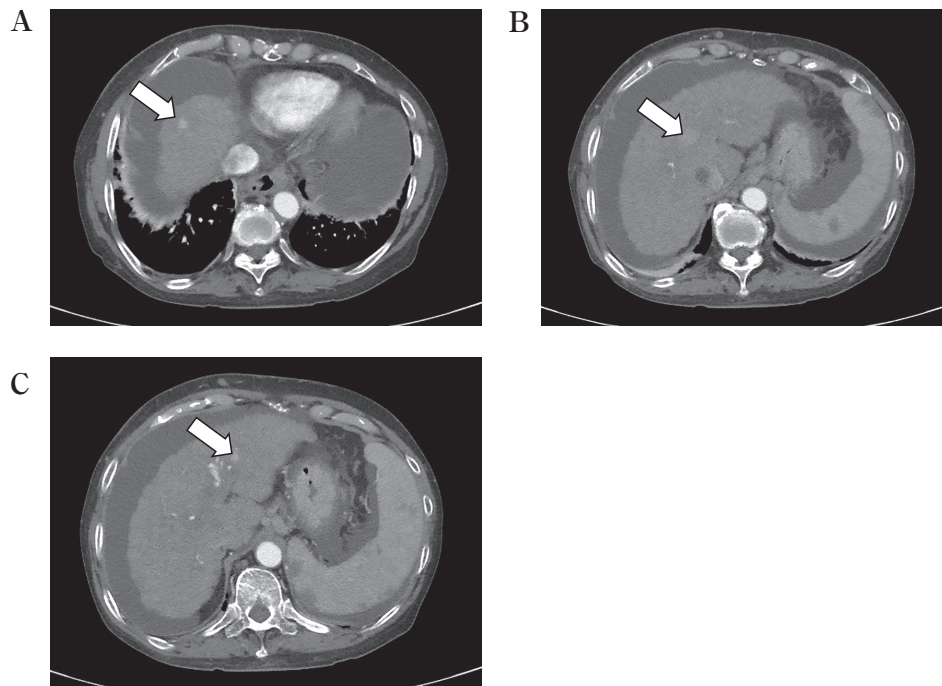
Preoperative CT images of the liver. (A) HCC, segment 8 (arrowhead ; 11 mm) ; (B) HCC, segment 4 (arrowhead ; 18 mm) ; (C) HCC, segment 3 (arrowhead ; 13 mm).
